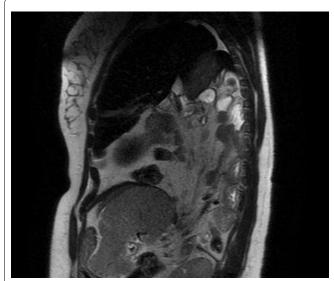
Sagital SSFSE T2-weigthed image, MRI
